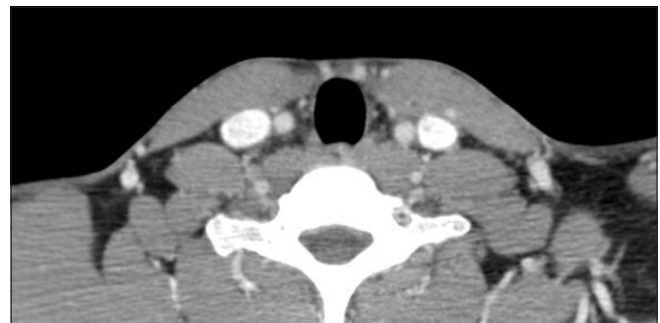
Axial computed tomography sections show absence of thyroid lobes at their anatomical location
